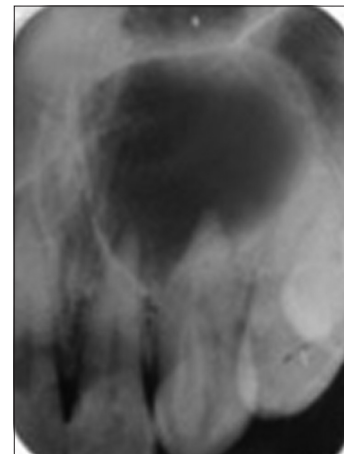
Radiograph showing dens invaginatus in tooth 22 with periapical lesion
